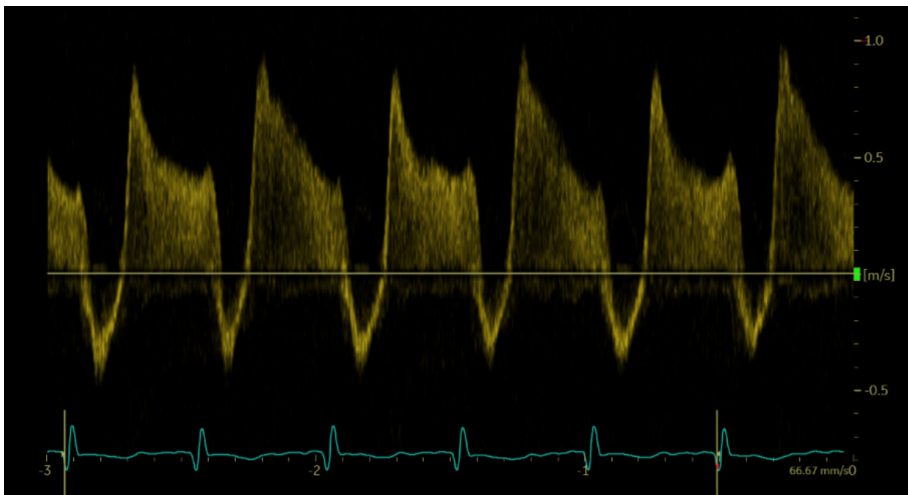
Doppler pulse wave measurements of ductus arteriosus flow
